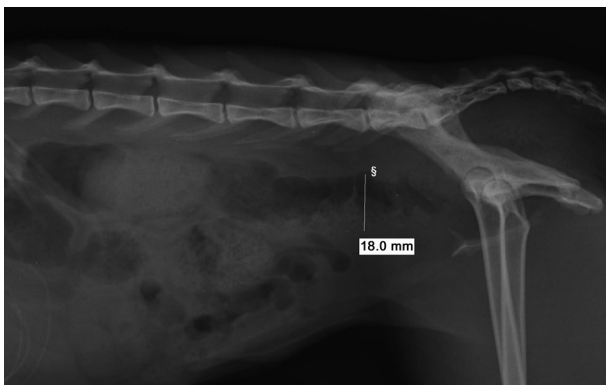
Right lateral abdominal radiograph taken 18 months after surgery
